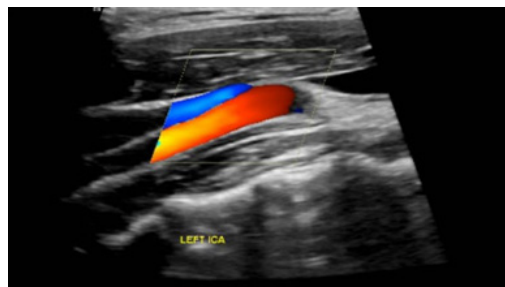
Carotid Doppler ultrasound of the left ICA: Grossly normal hemodynamic picture with no evidence of atheromatous plaques or stenosis.
